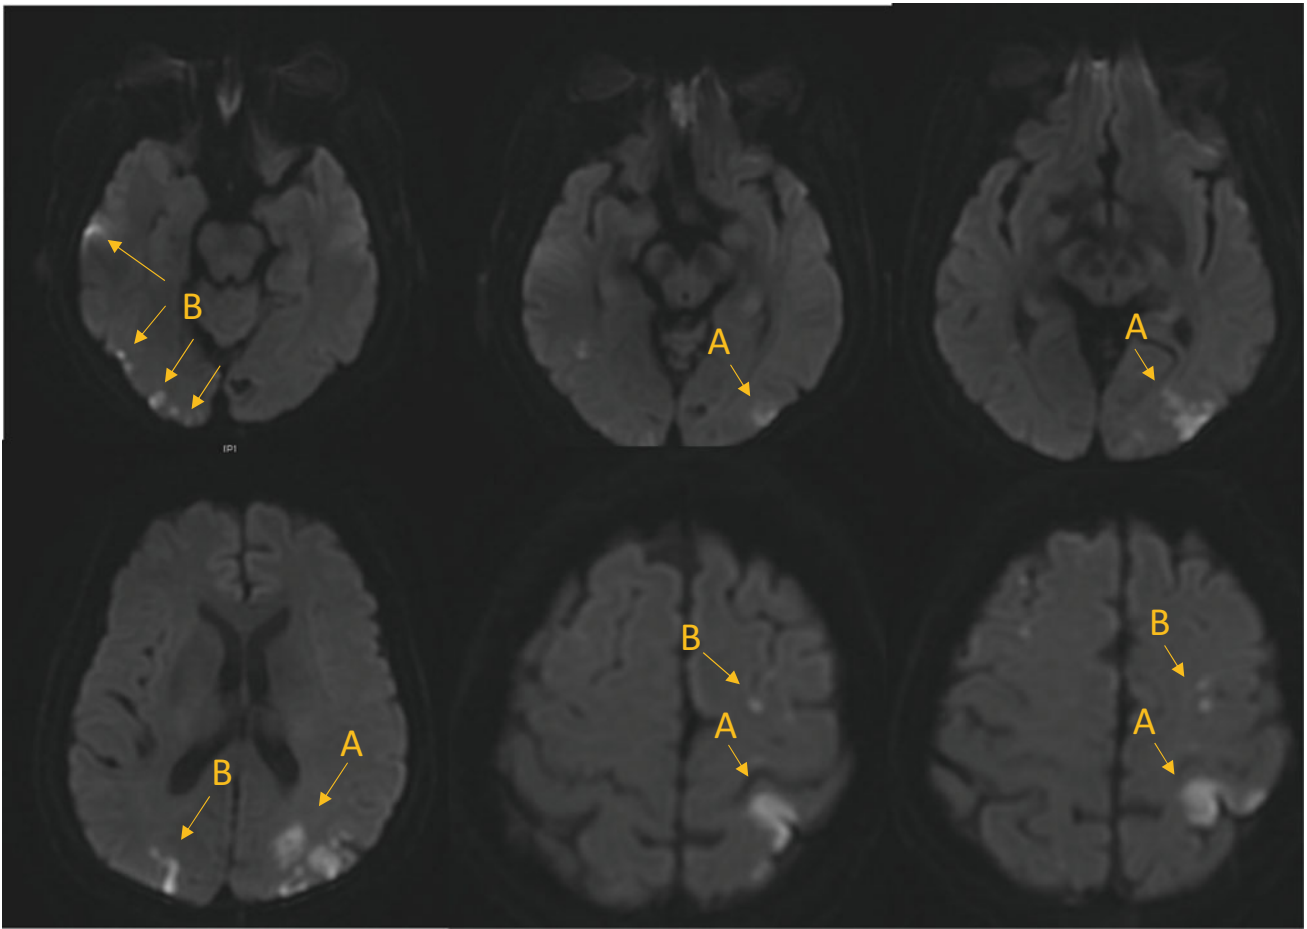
MRI diffusion-weighted imaging. Multiple areas of restricted diffusion within left parieto-occipital junction (A arrows) and additional smaller lesions within bilateral cerebral hemispheres (B arrows)
